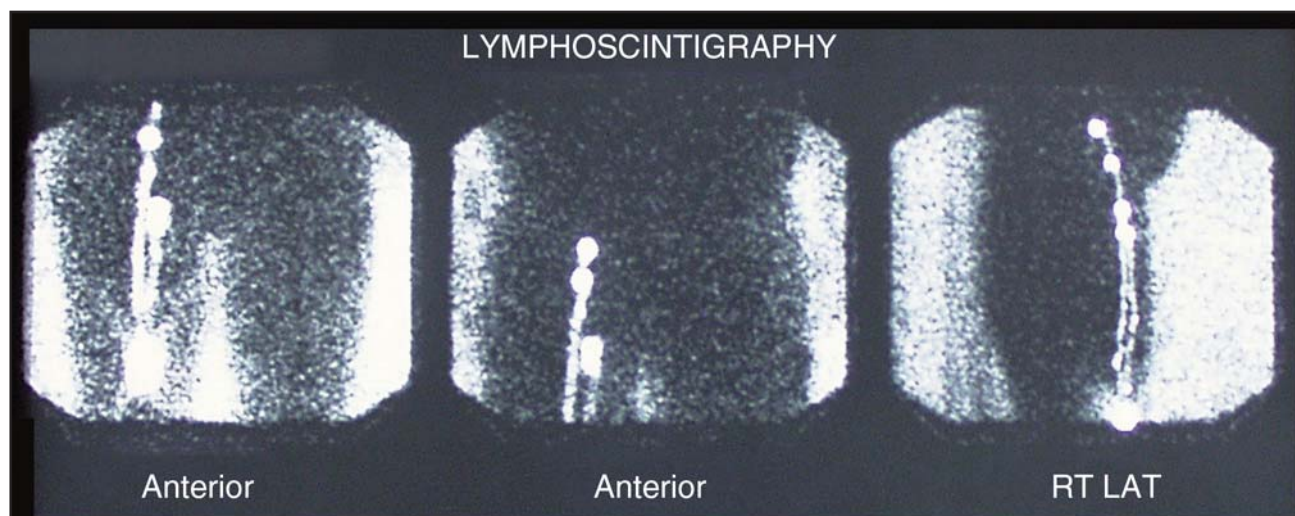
A lymphoscintigram demonstrating drainage of an anterior thigh melanoma directly to sentinel iliac nodes. On the lateral view, nodes with uptake are above the inguinal ligament and therefore beyond Cloquet’s node.
